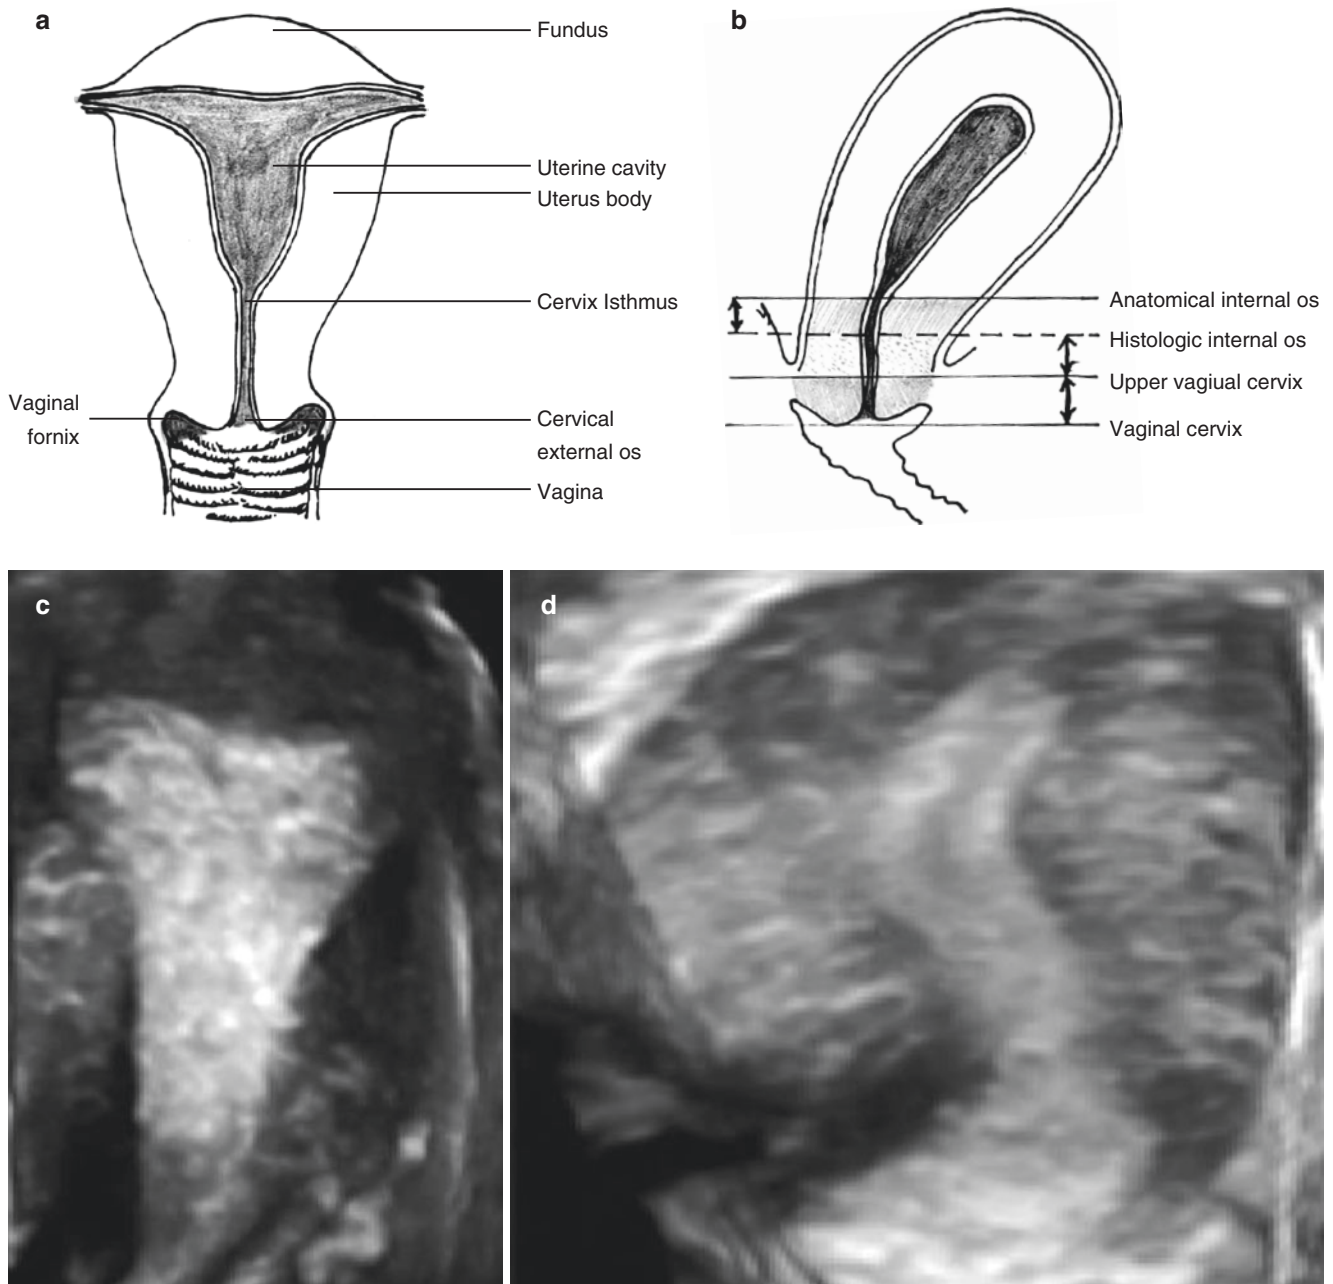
Anatomy of the uterus. (a). Coronal view of the uterus; (b). Sagittal view of the uterus; (c). Coronal view of uterus (3-D ultrasound); (d). Sagittal view of uterus (3-D ultrasound)
